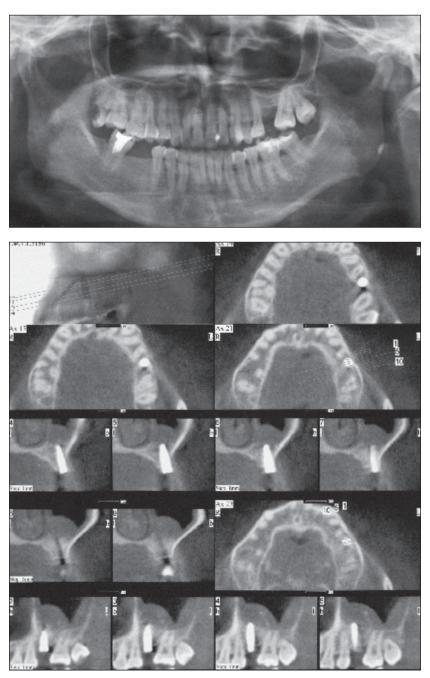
Preoperative panoramic radiograph showed the residual bone height to be 3.3 mm.
